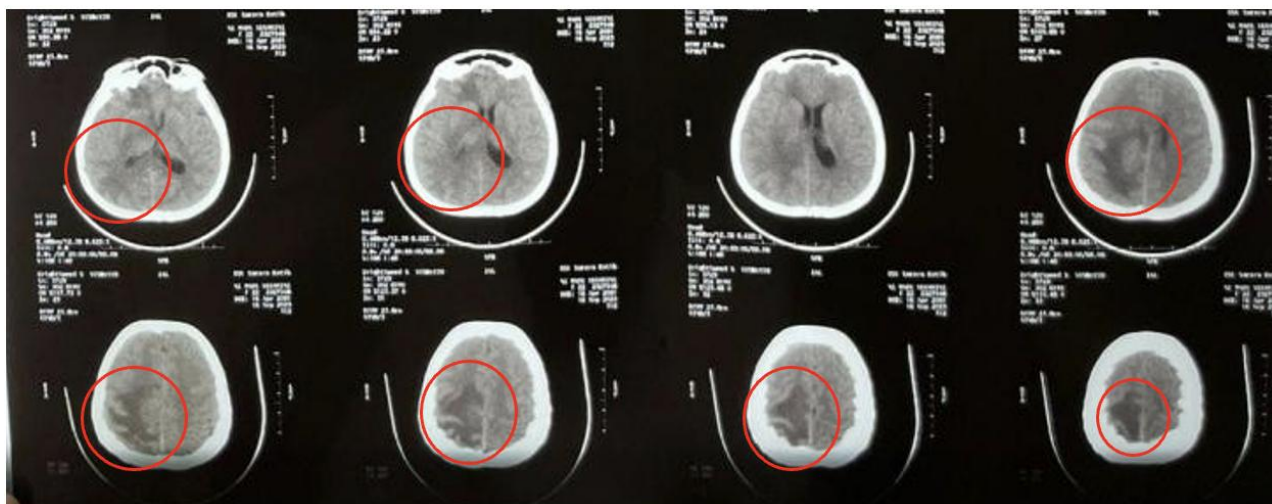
CT-scan of the head. The red rings reveal extensive vasogenic edema.
